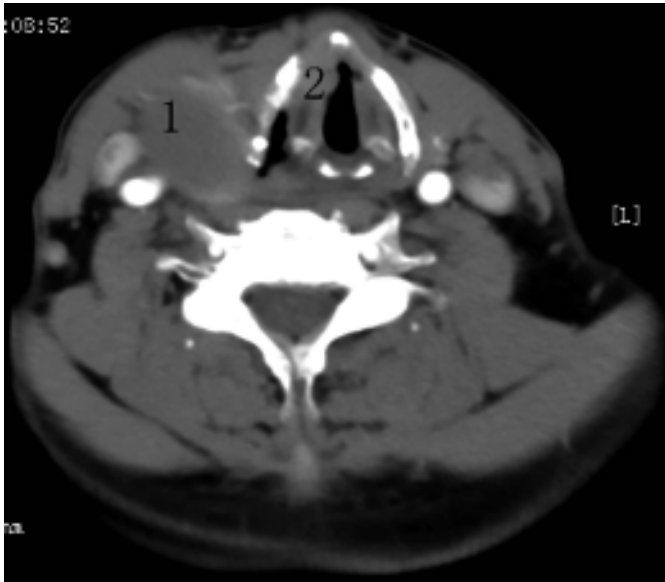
CT of the neck before surgery: multiple thyroid masses and nodular vocal cords. 1 Right goiter mass 2 Right vocal cord nodule.
